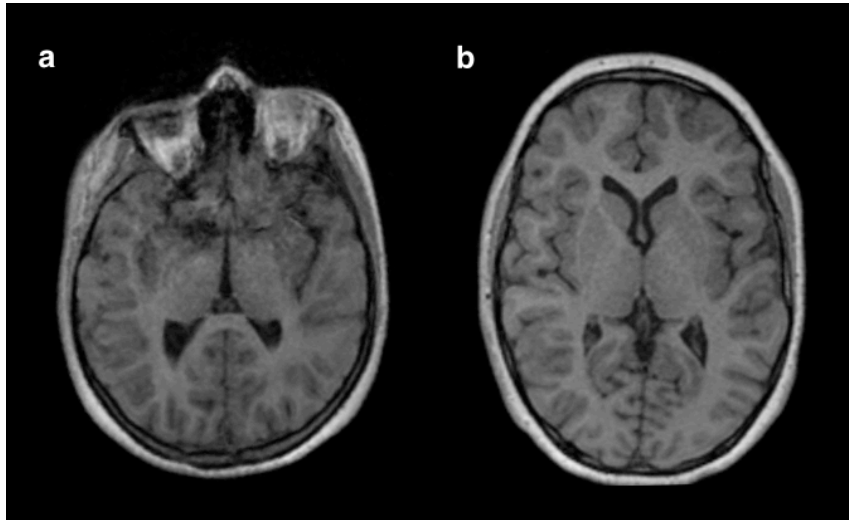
T1-weighted scans of cases with unilateral involvement of the peripheral visual system. a) 9 year-old girl with micro-ophthalmia, who had the left eye surgically removed b) 12 year -old girl with optic nerve hypoplasia on the right side. Axial images are shown on the level of the lateral ventricle to show the progression of the optic radiations along the ventricle.
